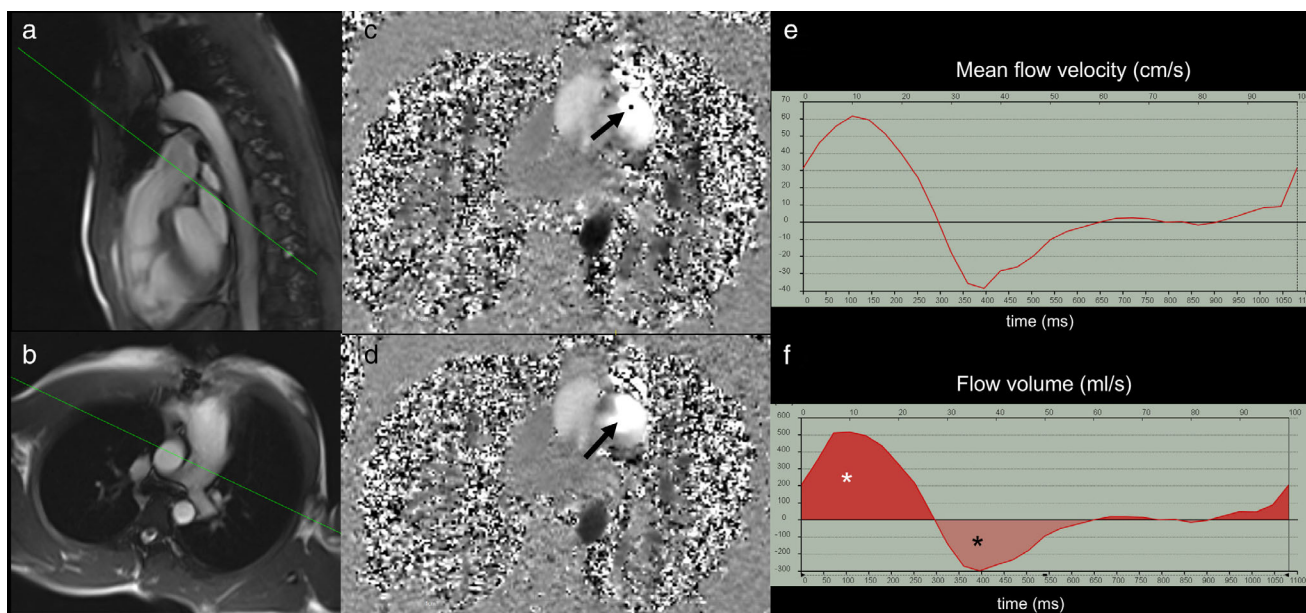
PC imaging of pulmonic regurgitation in a 16-year-old boy with tetralogy of Fallot who underwent surgical repair at 4 months of age. PC imaging of the pulmonary artery was performed by setting up a perpendicular scan plane on bSSFP oblique sagittal (a) and oblique axial (b) MR images. Phase images obtained using a VENC gradient of 150 cm/s (c) show a focal transition from high signal intensity to low signal intensity (arrow), consistent with aliasing. This was corrected using a VENC of 200 cm/s (d), and peak velocity was 180 cm/s. Phase contrast images can be used to generate quantitative flow parameters including mean flow velocity (e) and flow volume (f). The area under the positive portion of the flow volume curve (white asterisk) denotes forward flow volume, whereas the areas under the negative portion of the curve (black asterisk) denotes reverse flow volume. The regurgitant fraction was calculated at nearly 50%. The patient was managed with a transcatheter pulmonic valve replacement.
